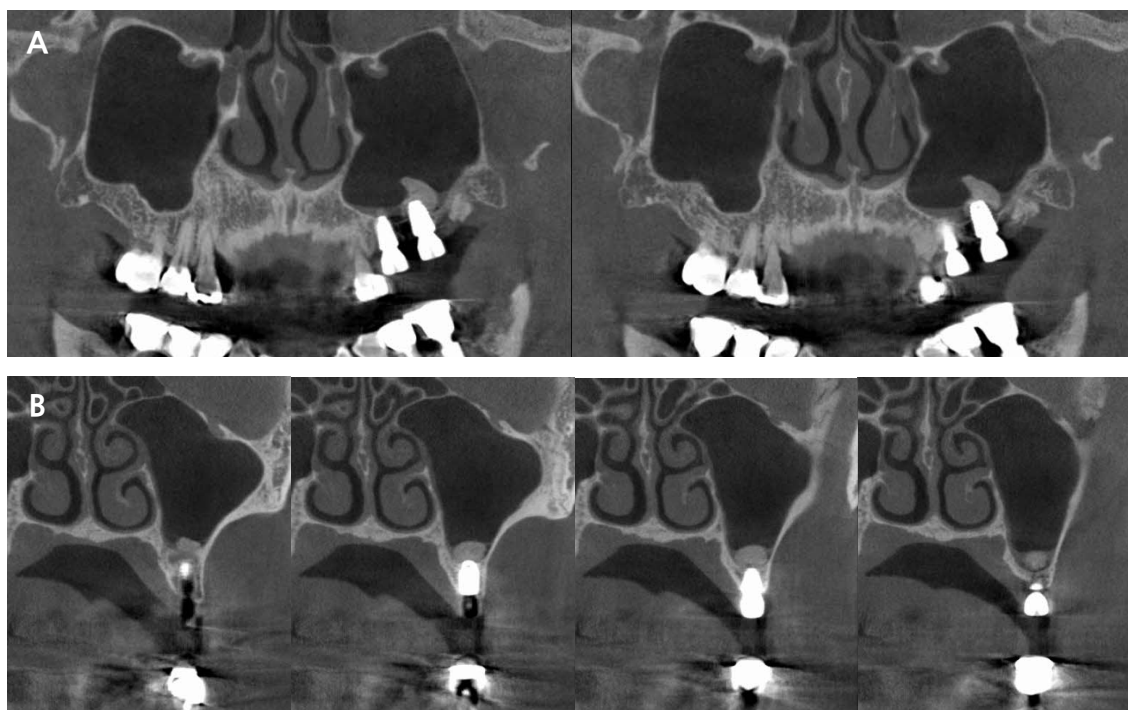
CBCT radiographs after surgery. (A) panoramic view, (B) Paraxial view.
